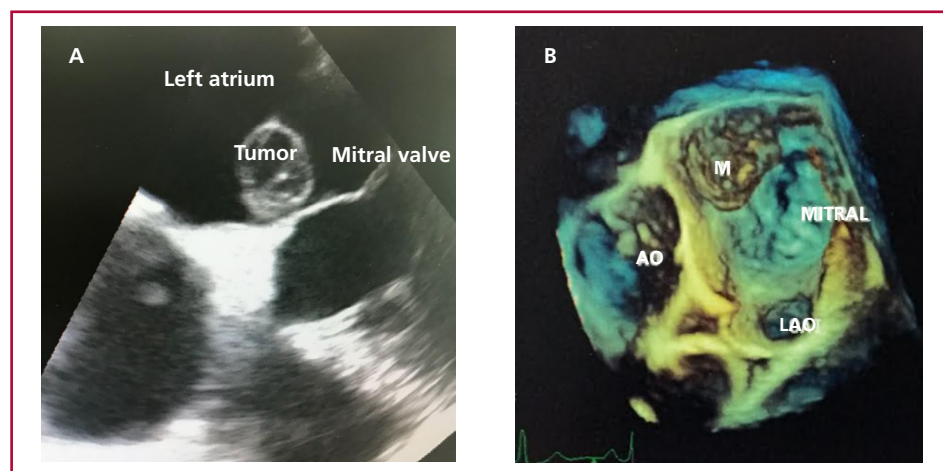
Echocardiographic images. A: Transesophageal echocardiography. B: Three-dimensional echocardiography
